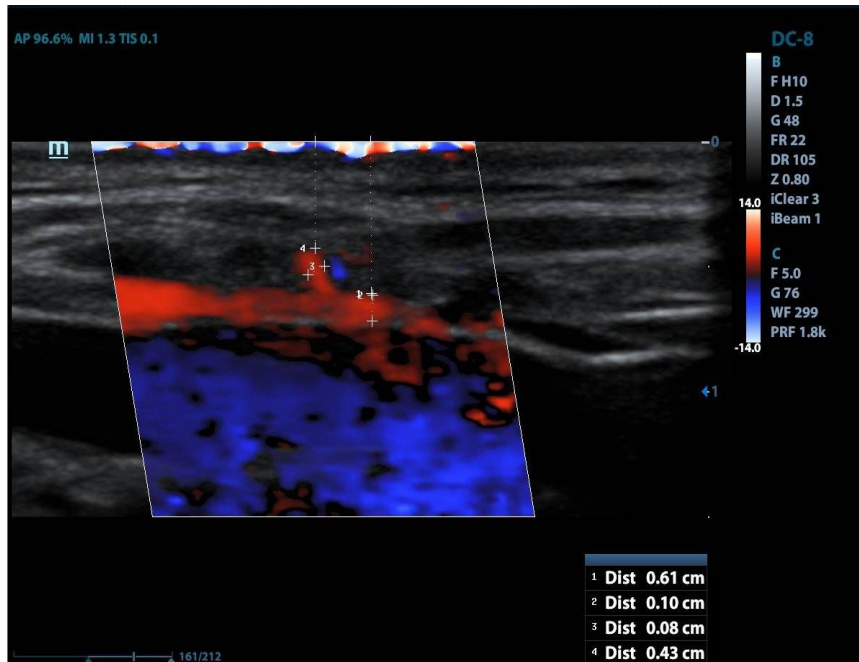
b: Triplex Ultrasonography shows the transverse cervical artery and supraclavicular branch. The size of supraclavicular artery is 0.8 mm and 0.43cm distance from the skin surface.
